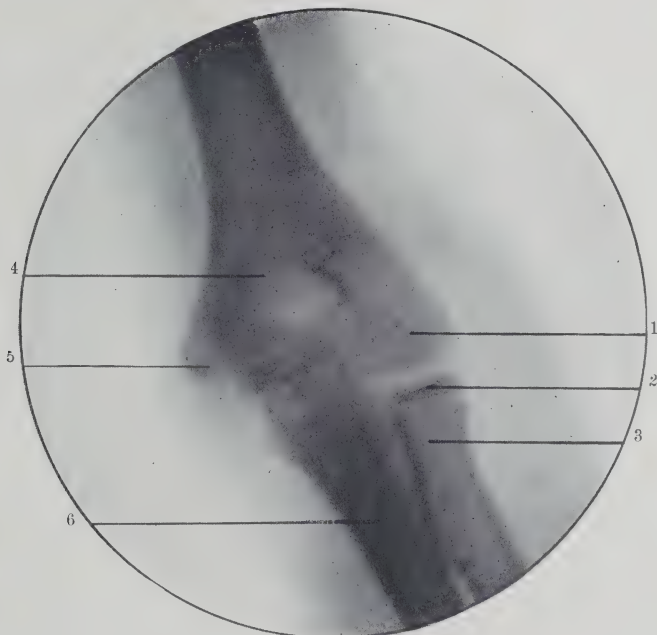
Radiograph Showing Vertical View of Elbow at Twelve Years. 1, Capitellum; 2, upper epiphysis of radius; 3, radius; 4, humerus; 5, trochlea; 6, ulna. (Original.)
